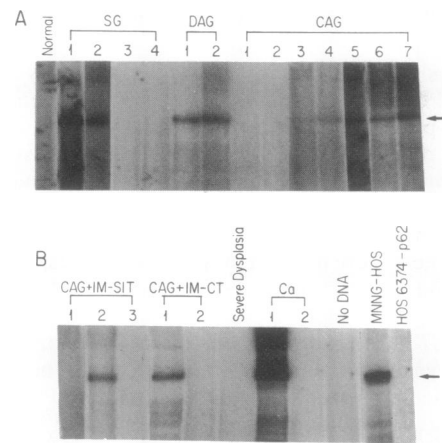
Expression of *TPR-MET* RNA in human gastric biopsy tissues and cell lines. (*A* and *B*) Autoradiograms of 7% native polyacrylamide gels showing a 205-bp DNA fragment spanning the *TPR-MET* breakpoint region of cDNA. (*A*) RNAs from 2×10^4 cells of the MNNG-HOS cell line and 5×10^4 cells of the HOS 6374 (passage 62) cell line were used per lane as positive and negative controls, respectively. The analysis was carried out in two separate experiments. SG (case 1) represents an overnight exposure of the autoradiograph (from the first experiment), whereas SG (case 2), CAG (cases 3, 6, and 7), CAG plus IM-SIT (intestinal metaplasia, small intestinal type; case 1), normal, MNNG-HOS, and HOS 6374 (passage 62) lanes represent a longer exposure time (3 days using Kodak x-ray film with a single intensifier screen). A negative control lane with no template RNA was also included (see *B*). Ca (case 1) is a short exposure (2 days with intensifier screen) of the autoradiograph from the second experiment, whereas all of the remaining lanes represent a prolonged exposure time (5 days) of the autoradiogram.
